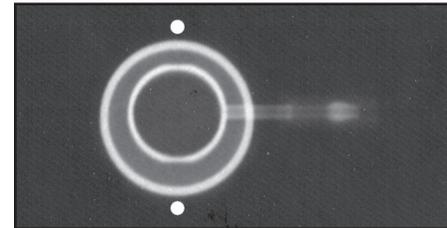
Top or bottom view x-ray image of the LAP-BAND AP® System Large Access Port
